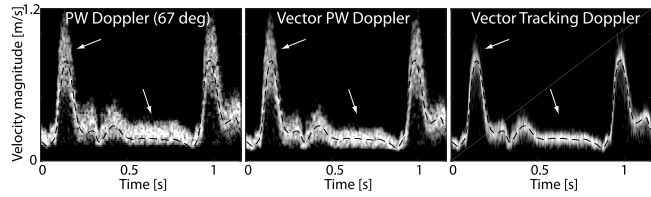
Spectral Doppler in the common carotid artery of a healthy volunteer using manual angle correction (left), automatic angle correction (middle), and automatic tracking angle (right). Black dashed line: vector Doppler velocity magnitude.
